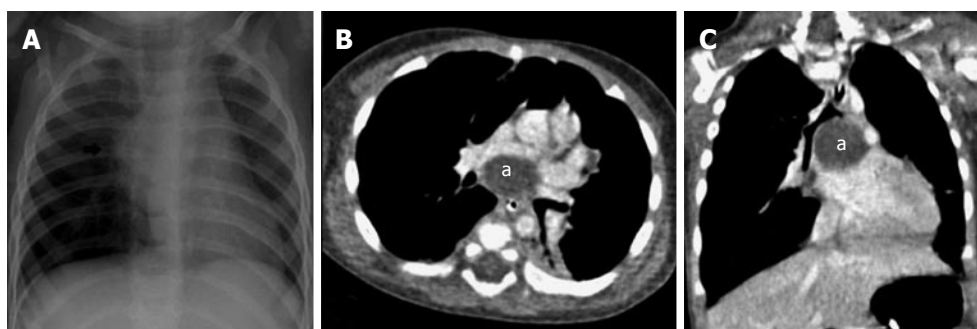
Subcarinal bronchogenic cyst. Frontal radiograph of chest (A) reveals mediastinal widening (arrow). Contrast enhanced axial (B) and coronal MPR (C) images reveal well defined non-enhancing homogenous fluid attenuation lesion in subcarinal location (a) narrowing the bronchial divisions with resultant subsegmental atelectasis in left lower lobe. MPR: Multiplanar reformation.
